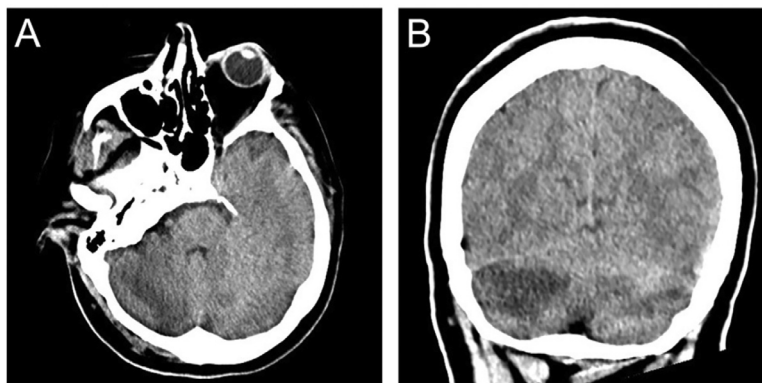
Initial head CT. (A) Axial and (B) coronal head CT images demonstrate bilateral cerebellar hypodensities.
